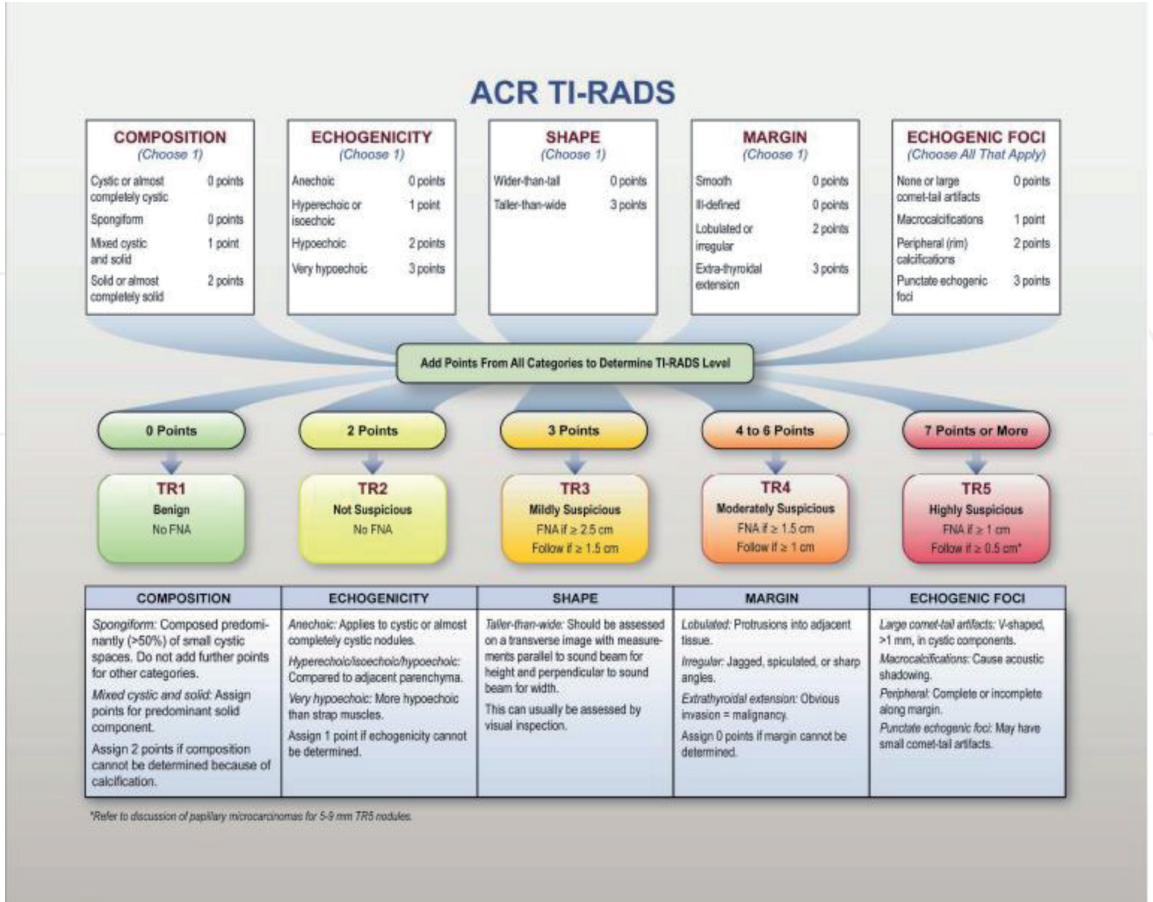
Sonographic characteristics of thyroid nodules (Adapted from ATA guidelines for adult patients with thyroid nodules and differentiated thyroid cancer [1]).
